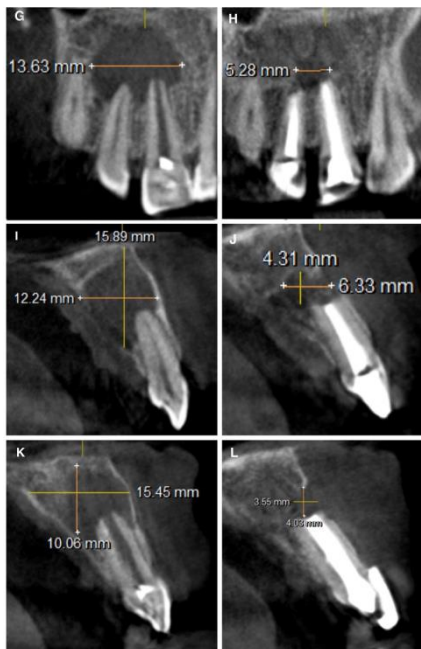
(G) Pre-op CBCT image showing the lesion measurement in the coronal slice (H) Post-op CBCT image showing the lesion measurement in the coronal slice. (I) Pre-op CBCT image showing the lesion measurement in sagittal slice corresponding to 12. (J) Post-op CBCT image showing the lesion measurement in sagittal slice corresponding to 12. (K) Pre-op CBCT image showing the lesion measurement in sagittal slice corresponding to 11. (L) Post-op CBCT image showing the lesion measurement in sagittal slice corresponding to 11.
